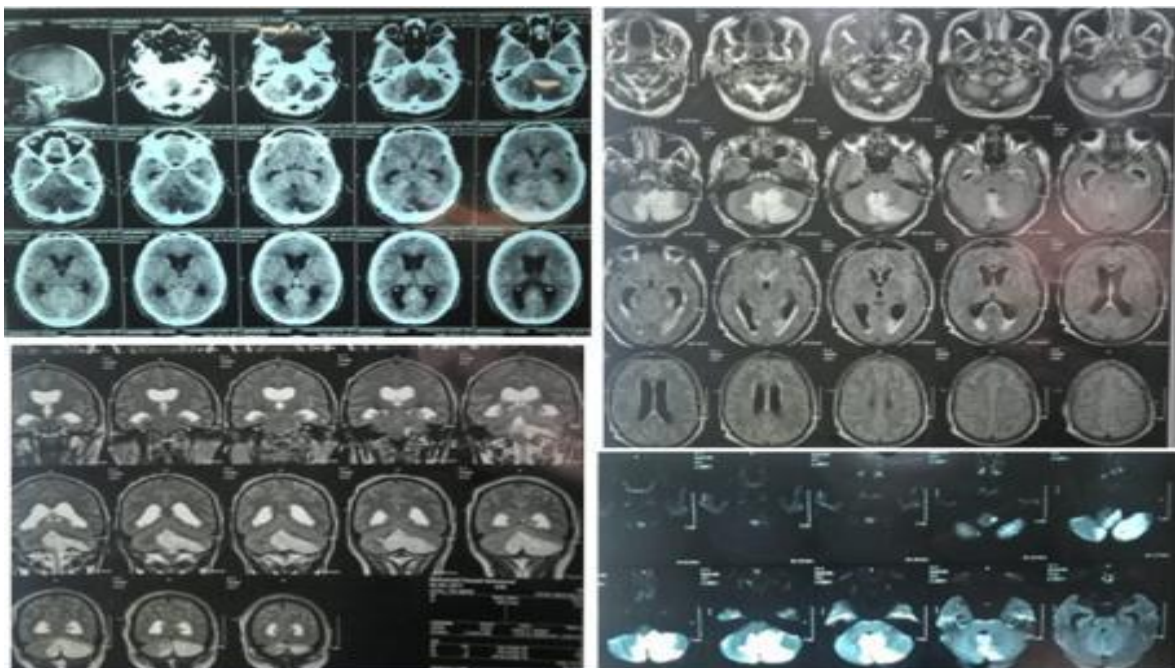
A: Preoperative CT and MRI scans of Case 2.
